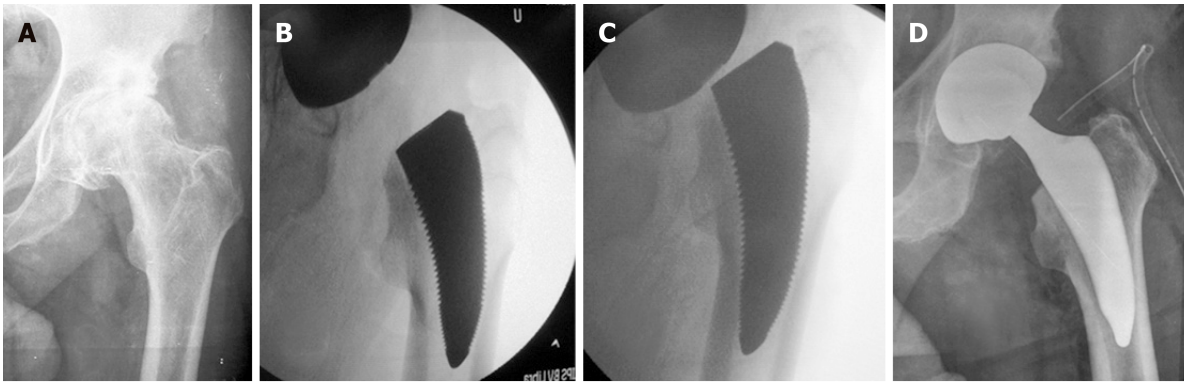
The appropriate size and orientation of the femoral component were ensured with fluoroscopy after the trial reduction in all cases. A: Pre-operative radiograph; B: Intra-operative fluoroscopy after the trial reduction showing a varus and undersizing rasp; C: Correct orientation and sizing; D: Immediate postoperative radiograph.
